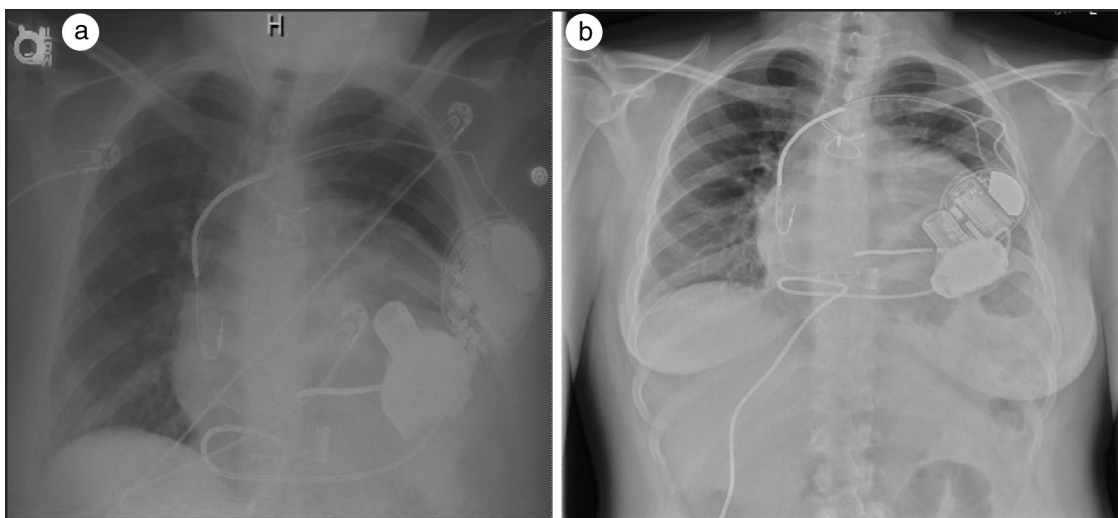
Chest x-ray (a) in the postoperative period showing no edema or intrapleural markings and (b) 2 months after delivery depicting no focal consolidation or edema, an enlarged cardiac silhouette, and the LVAD present and properly positioned.
